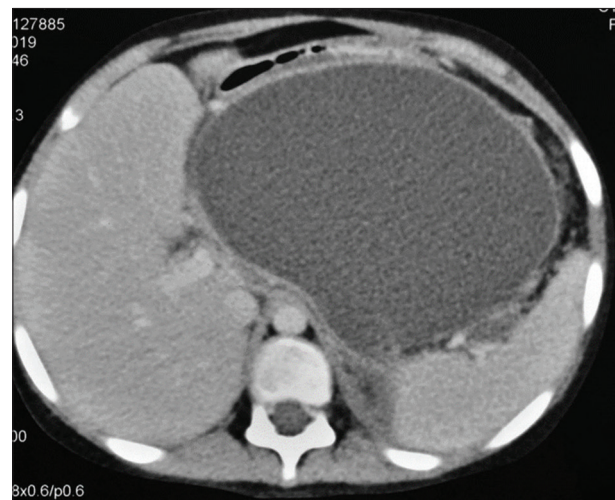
Computed tomography of the abdomen, showing a large walled-off necrosis
